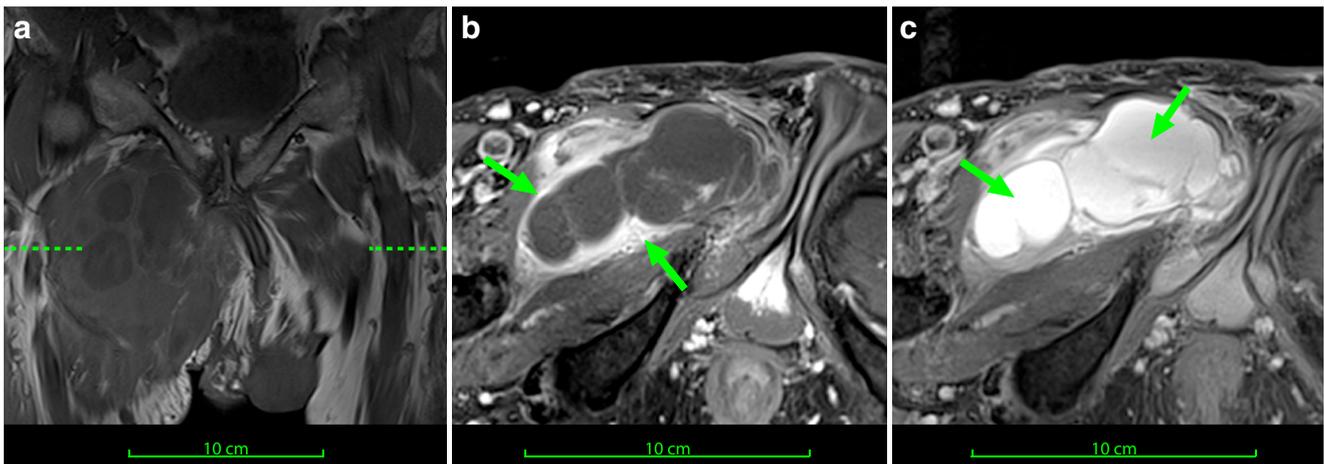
Follow-up MRI shows inhomogeneous enhancement of the rim and septa as before (*arrows*; coronal T1 TSE FS pre-contrast; a and axial T1 TSE FS post-contrast; b). Very delayed-phase image series acquired 90 min after contrast media injection demonstrate extensive contrast
